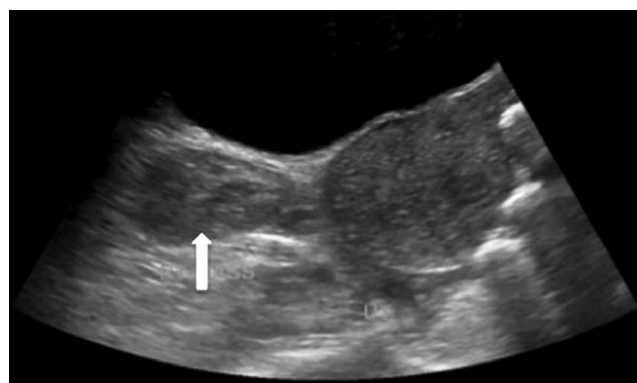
Longitudinal transabdominal ultrasound demonstrates a normal fluid-distended bladder, the uterus, and a 6.3 × 4.4-cm right adnexal mass (arrow) separate from the uterus.
